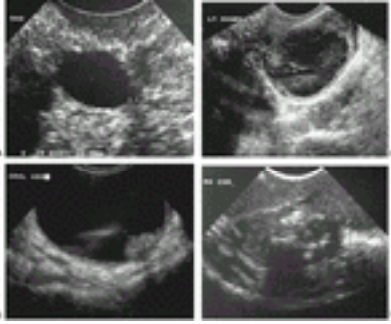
Pelvic masses. A: Transvaginal sonogram of a smooth-walled cyst (between cursors) exhibiting the sonographic features consistent with a functional or physiologic cyst. B: Hemorrhagic corpus luteum with organized hemorrhage containing thin fibrin strands and internal echoes within the mass. C: Papillary excrescence arising from the wall of a mostly cystic ovarian mass. This morphologic feature is highly suggestive of cancer. D: Mass containing several echogenic foci and solid areas indicative of a dermoid cyst.
